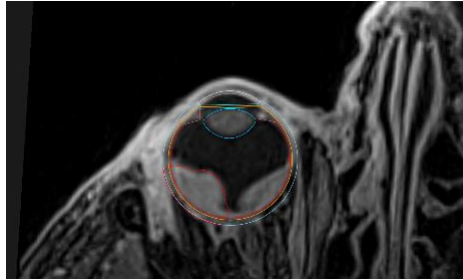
Eye model from RayOcular software overlapped to MRI acquisition.
